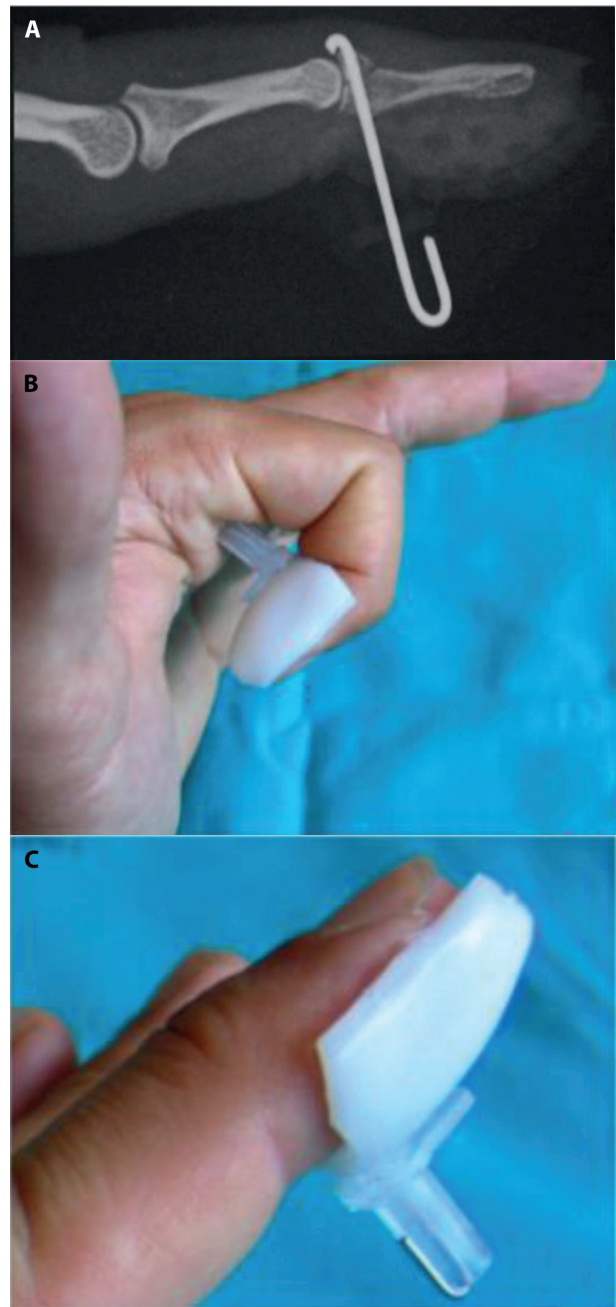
Post-operative radiography (a) and clinical picture (b) of a MF treated by the mean of the Umbrella technique, with the custom-made thermoplastic splint in place.
